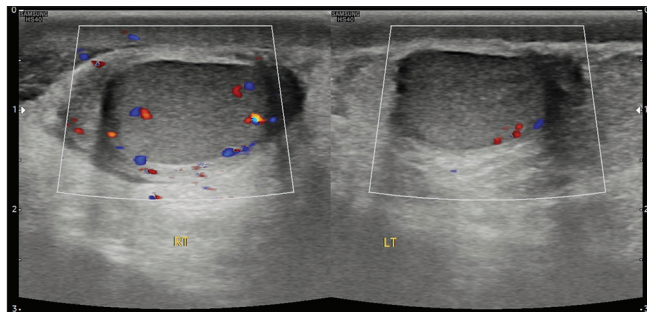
A color Doppler ultrasound of both testes in the longitudinal plane. RT: Right; LT: Left
